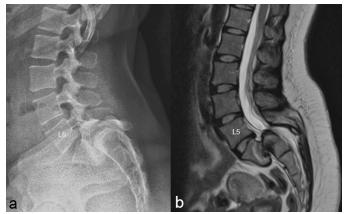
Lateral lumbar radiograph (a) and midsagittal T2-weighted magnetic resonance (MR) image (b) reveal six lumbar-type vertebrae. The L6 vertebral body is trapezoidal shaped and has translated 80-90% anteriorly in relation to the S1 vertebral segment. A large gap is present in the region of the L6 pars interarticularis and has resulted in posterior translation of the spinous process and laminae of L6. The L6-S1 disc is obliterated and prominent buttressing of the anteriorinferior aspect of the L6 vertebral body is present. The L5-L6 disc appears well hydrated, but is narrowed and bulging posteriorly. The posterior elements of L5 approximate the posterior aspect of the sacral base resulting in prominent central stenosis at this level.
